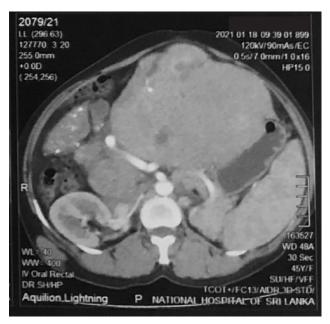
CT of the abdomen demonstrating bilateral disease
